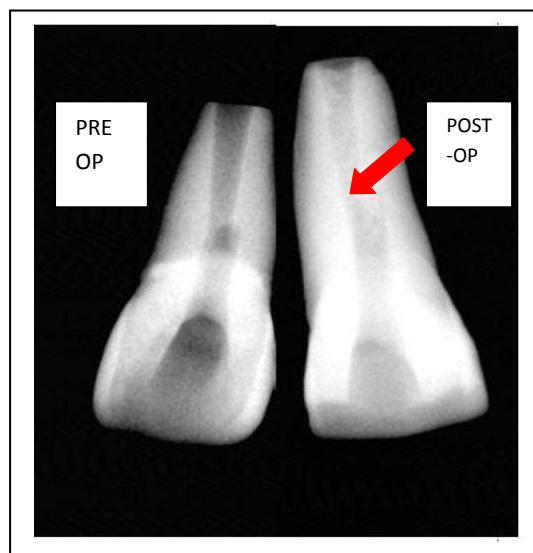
b Pre-OP radiograph of 11(Left-side) with an open apex . Post-OP (Right- side) radiograph shows increased amount of radiopacity obtained within root canal when PRF+50wt% nHA used as apexification material
